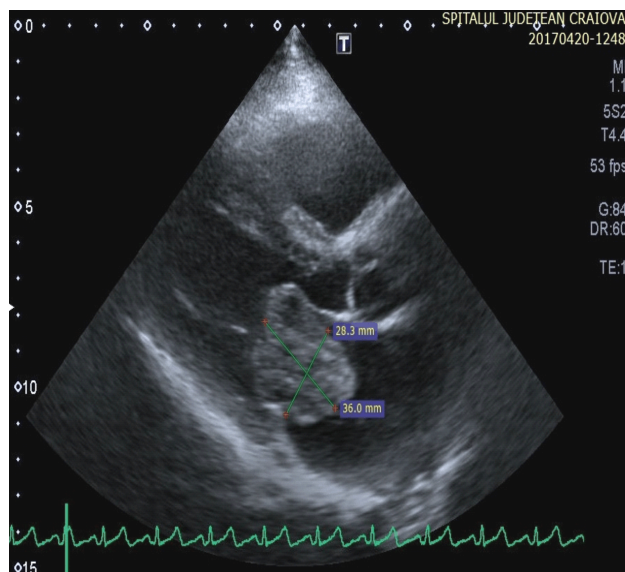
Transthoracic echocardiography (TTE), parasternal long axis view: large atrial tumor (myxoma) passing through the mitral valve in diastole.
